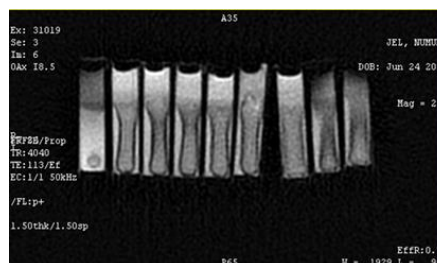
Sagittal plane MR images of the gel samples. Unirradiated leftmost side, irradiated samples with increasing amount 50 cGy - 100 cGy - 200 cGy - 400 cGy - 600 cGy - 800 cGy - 1000 cGy and 2000 cGy from left to right.
